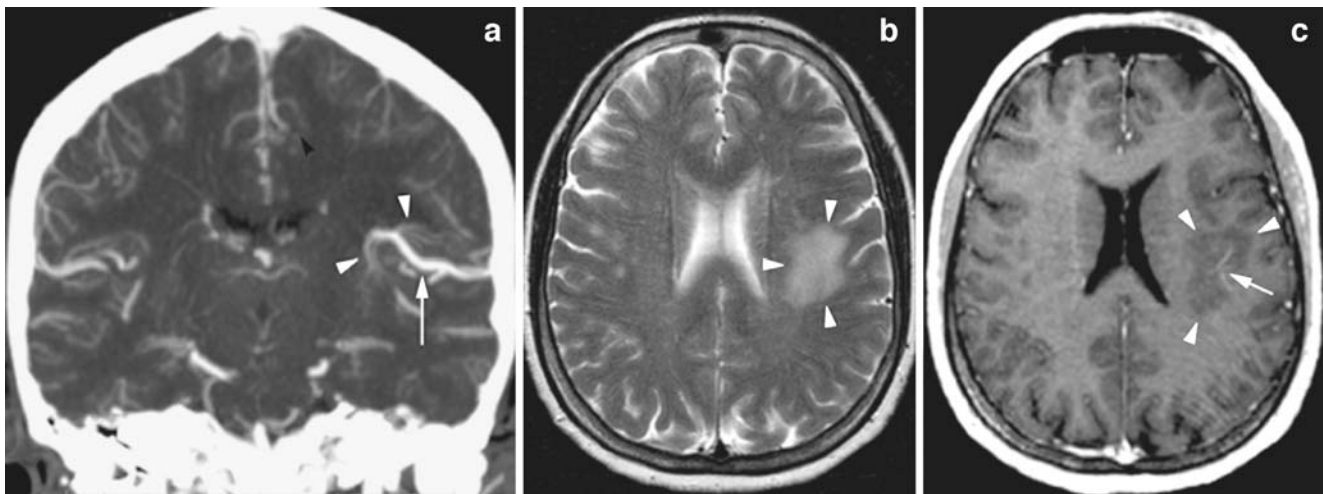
A 56 year-old female presenting with a Guillain–Baré syndrome with bilateral 6th cranial nerve palsy. Brain MRI disclosed an incidental white matter lesion centred upon a small DVA with superficial drainage. a Coronal multiplanar reconstruction (MPR) of an a CT angiography (CTA), showing the left insular DVA with the typical caput medusa (*arrowheads*) centred around a collecting vein (*arrow*). b MR imaging, axial T2-W images, showing a hyperintense subcortical white matter lesion around the left insular region (*arrow-*
